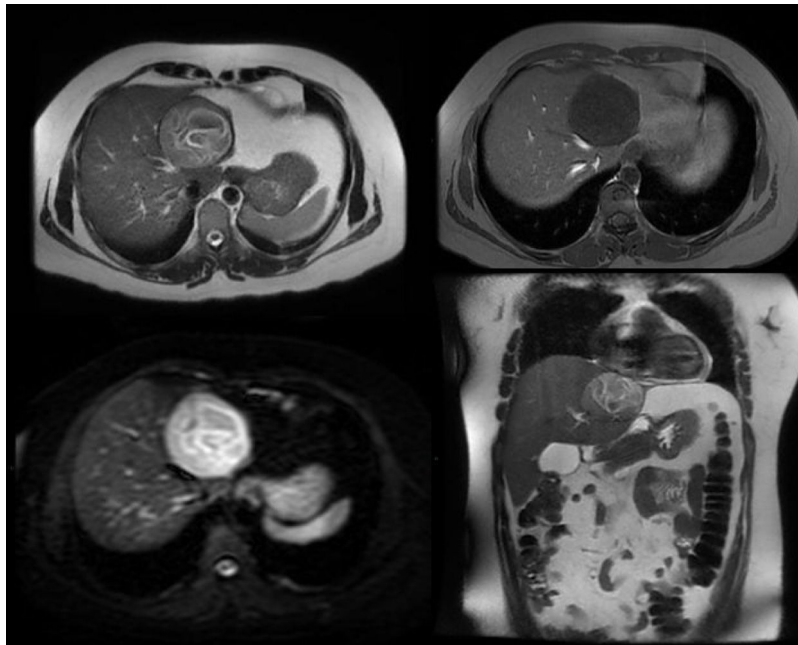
A contrast-enhanced MRI was performed.
